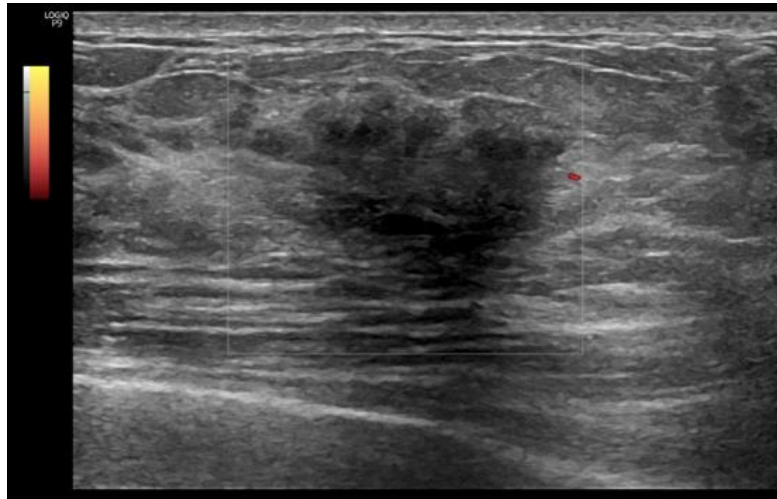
Doppler color ultrasound with absent vascularity
